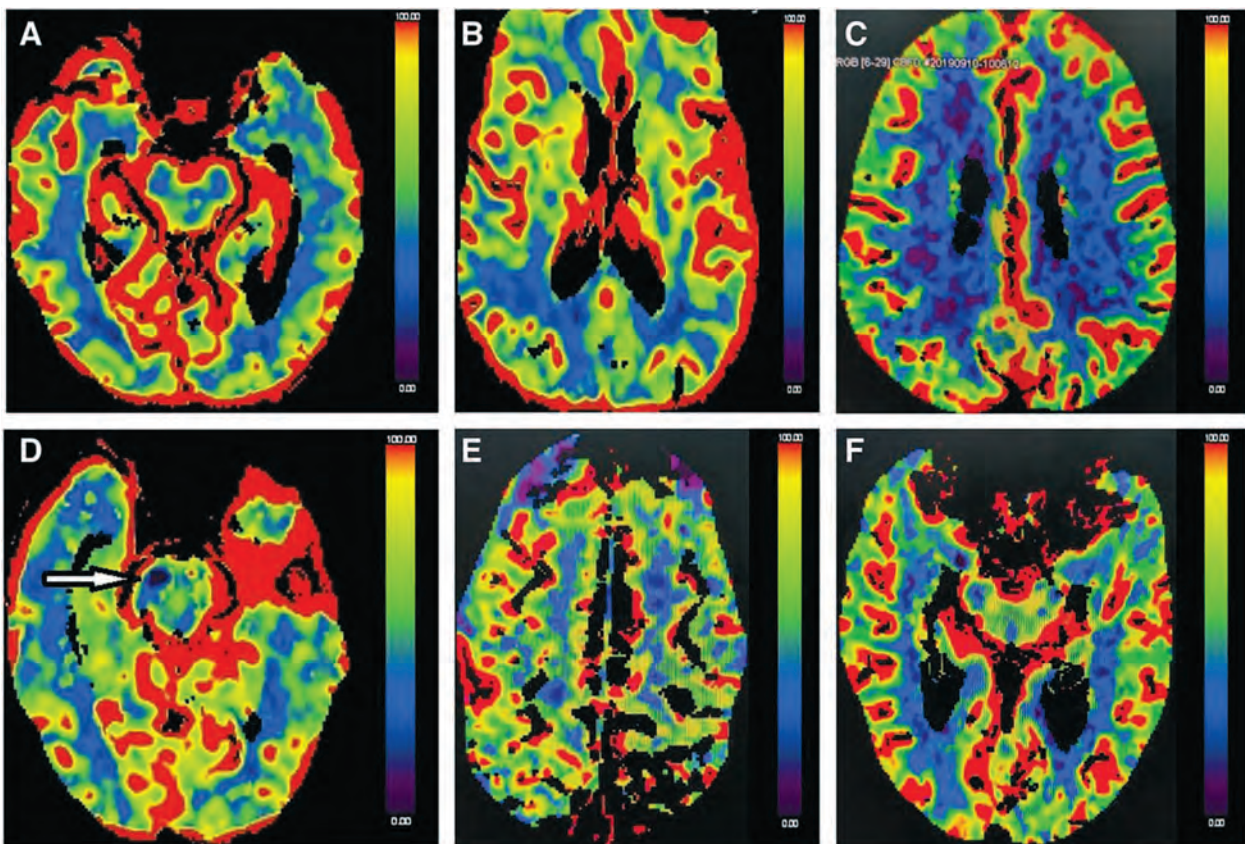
(A, B) CBF colour maps of a 55-year-old-man with transient focal motor deficit and no cognitive impairment (control) shows good perfusion seen as red-yellow colour in bilateral temporal regions and hippocampi (A) as well as in bilateral frontoparietal regions and basal ganglia (B). (C, D) CBF colour maps of a 67-year-old woman with VaD who had progressive decline in memory (MOCA score 18/30) show significant white matter hypoperfusion in bilateral frontoparietal white matter (C) with a focal perfusion deficit in right middle cerebral peduncle (white arrow) suggestive of lacunar infarct (D) which was not evident on NCCT of the patient (not shown). (E, F) CBF colour maps of a 67-year-old man with AD who had progressive cognitive impairment (MOCA score 11/30) show significantly reduced CBF in bilateral frontal regions (E) and right medial temporal region (F). AD, Alzheimer's disease; CBF, cerebral blood volume; MOCA, Montreal Cognitive Assessment; VaD, vascular dementia; NCCT - non-contrast CT.
